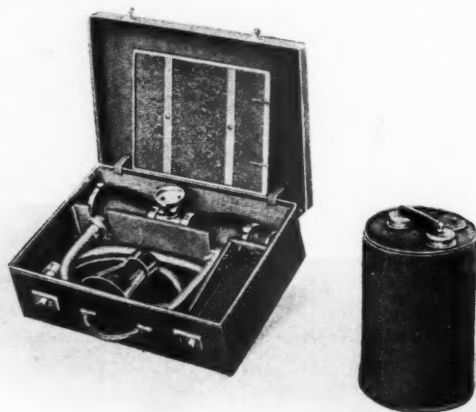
"The transformer, the X-ray tube, and the connecting cables can be made of small dimensions. The apparatus can easily be transported in two small cases."
